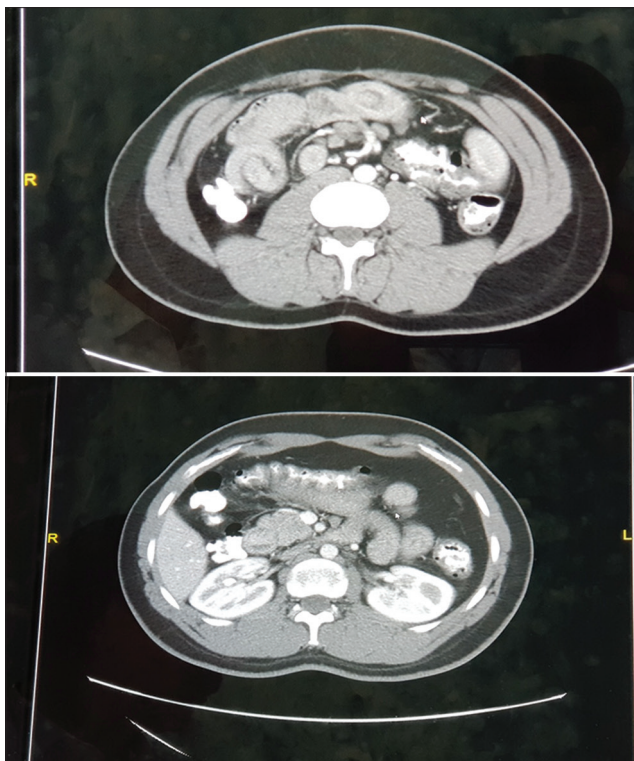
Computed tomography abdomen showing jejunal loop intussusceptions with diffuse jejunal wall thickening
